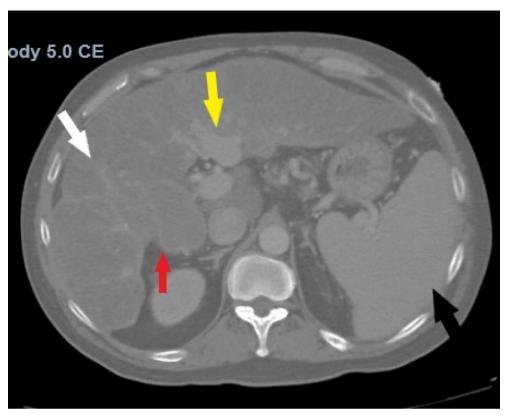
Computerized tomography (CT) of the Abdomen and Pelvis with intravenous (IV) Contrast. Sagittal views of the abdomen demonstrating extensive liver nodularity (white) indicative of cirrhotic disease, enlarged portal veins (yellow) and splenomegaly (black). Gallbladder is thickened with outer wall haziness (red) possibly indicative of inflammation or adjacent hepatic disease.
